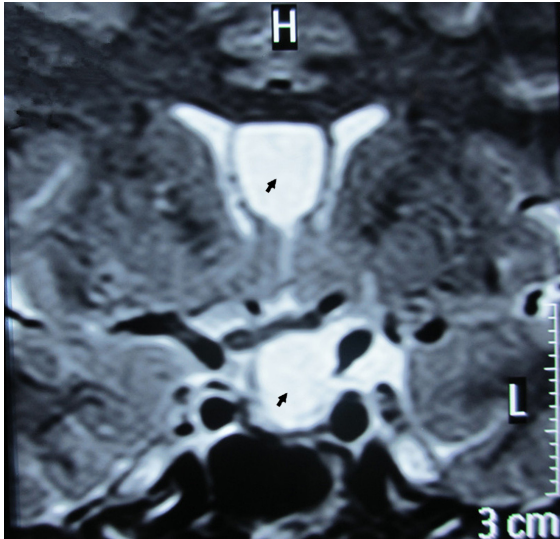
MRI T2 image showing a well-circumscribed space-occupying cyst in the sellar region (lower arrow) and a 13-mm cavum septum pellucidum cyst (upper arrow).
